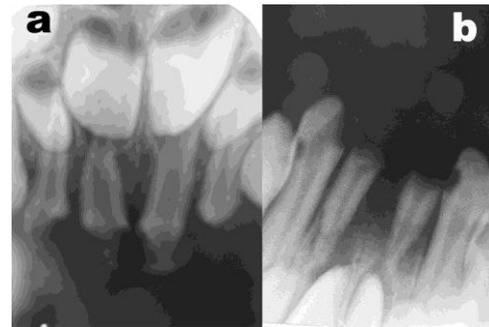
Pre operative IOPA radiographs (a. maxillary incisors b. mandibular incisors)
